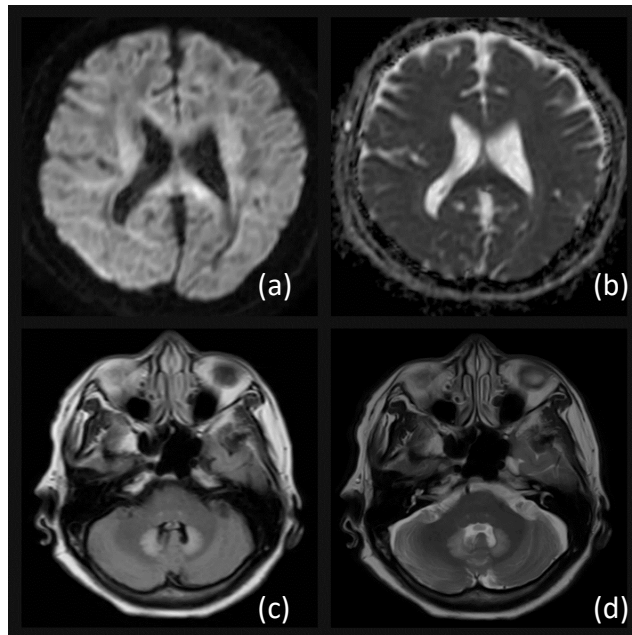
(a): ADC image showing partial diffusion restriction in corpus callosum. (b): DWI image showing partial diffusion restriction in corpus callosum. (c): FLAIR image showing high signal intensity in bilateral dentate nuclei. (d): T2 weighted image showing high intensity in bilateral dentate nuclei
